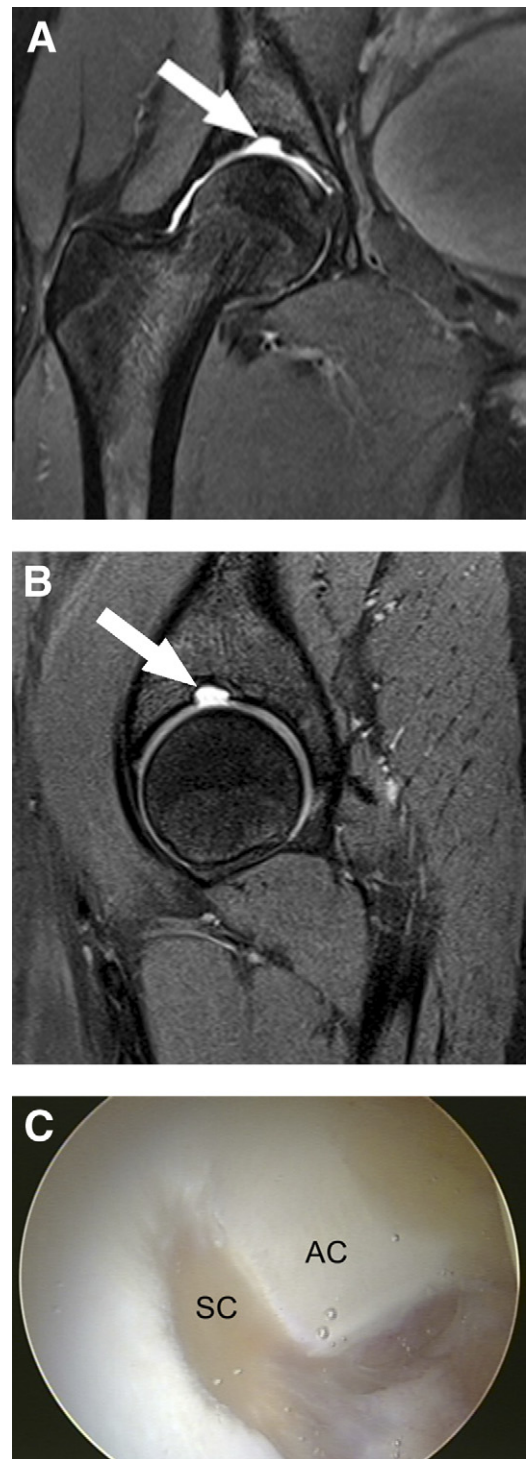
(A, B) T2 MRI scans with fat suppression of the right hip of a 15-year-old female patient. The images show an immature stellate crease (arrow) on the coronal view (A) and axial oblique view (B). (C) Intraoperative view of stellate crease in same patient. The immature stellate crease seen in adolescent patients should not be confused with chondral damage. (AC, acetabulum; SC, stellate crease.)
